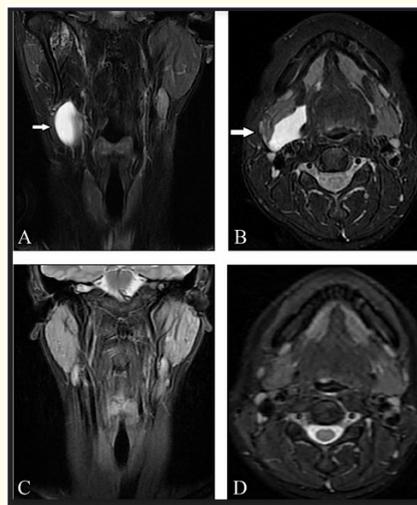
(A, B) Initial T2-weighted magnetic resonance imaging (MRI) shows a 5.8 x 3.0 x 2.4 cm plunging ranula (arrows) in the right submandibular space on coronal and axial imaging, respectively. (C, D) Follow-up T2-weighted MRI obtained 1 year after bleomycin sclerotherapy depicts total shrinkage of the plunging ranula.
